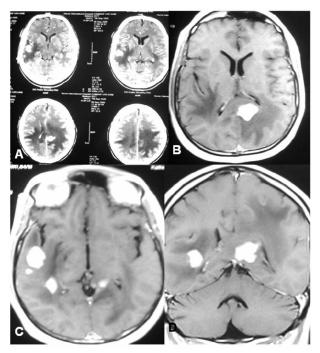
First CT and MRI images showing multiple well enhancing intra axial lesions involving posterior aspect of corpus callosum
